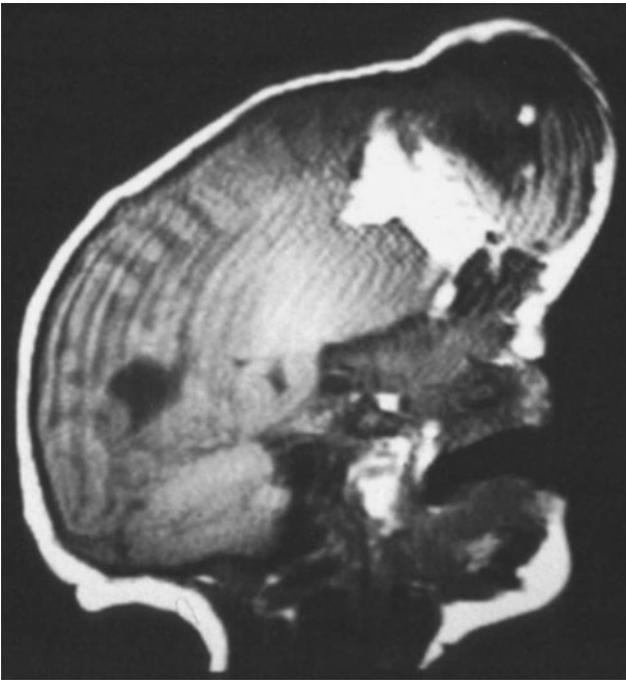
Sagittal T1-weighted magnetic resonance image of a patient with a large interfrontal encephalocele.
